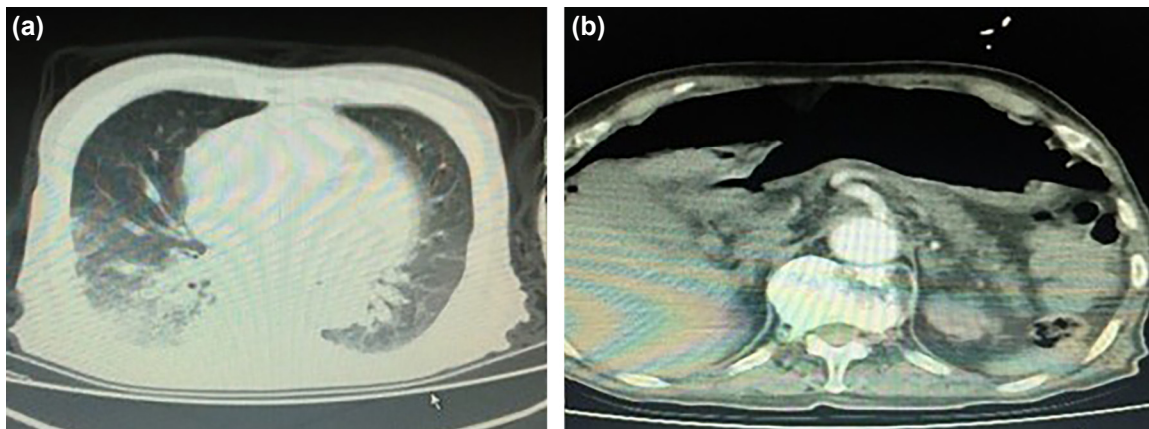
(a, b) Findings of perforation and COVID-19 in computed tomography
